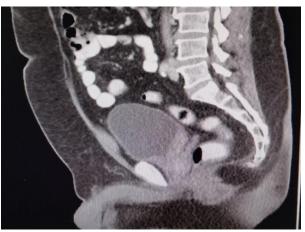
Computed Tomography scan showing tumor in sagittal plane that demonstrated poor fat plane between tumor and the prostate
